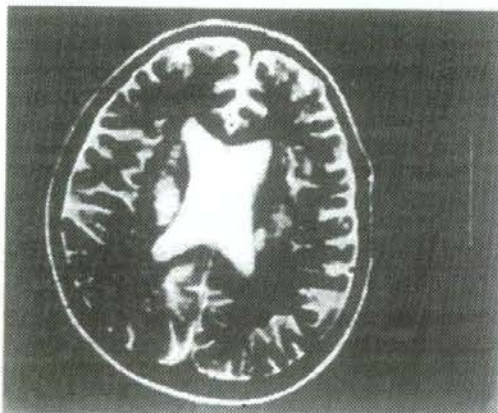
High signal intensity in the right corona radiata and left basal ganglia on T2-weighted magnetic resonance imaging.
